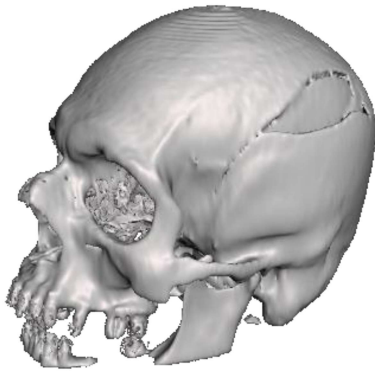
3D model of the skull after segmentation of the CT images in 3D Slicer. The fracture is visible on the left side of the patient.
